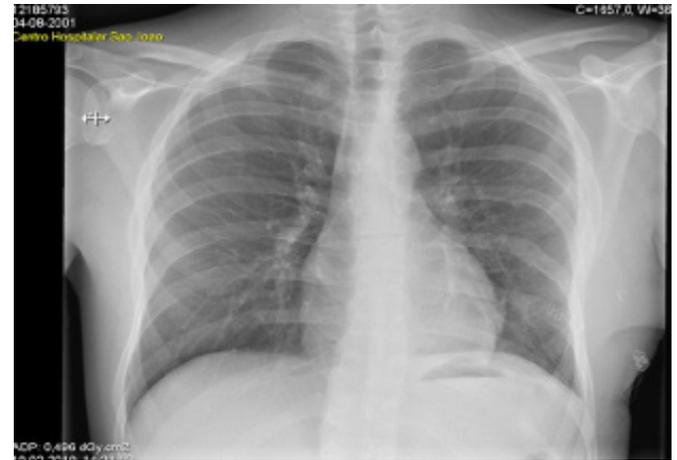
CT Radiology exams after surgery
